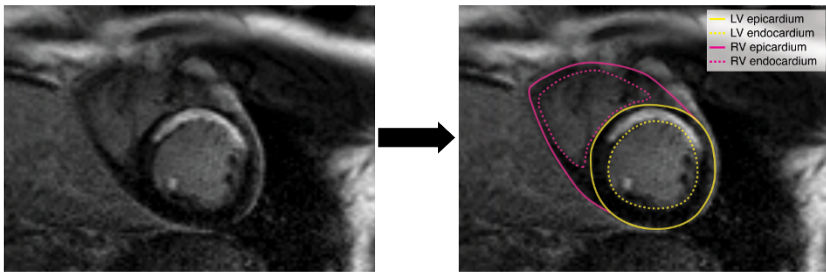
Left: Short axis LGE MRI. Right: Contours of the epicardium and endocardium of the left ventricle (LV) and the right ventricle (RV).
